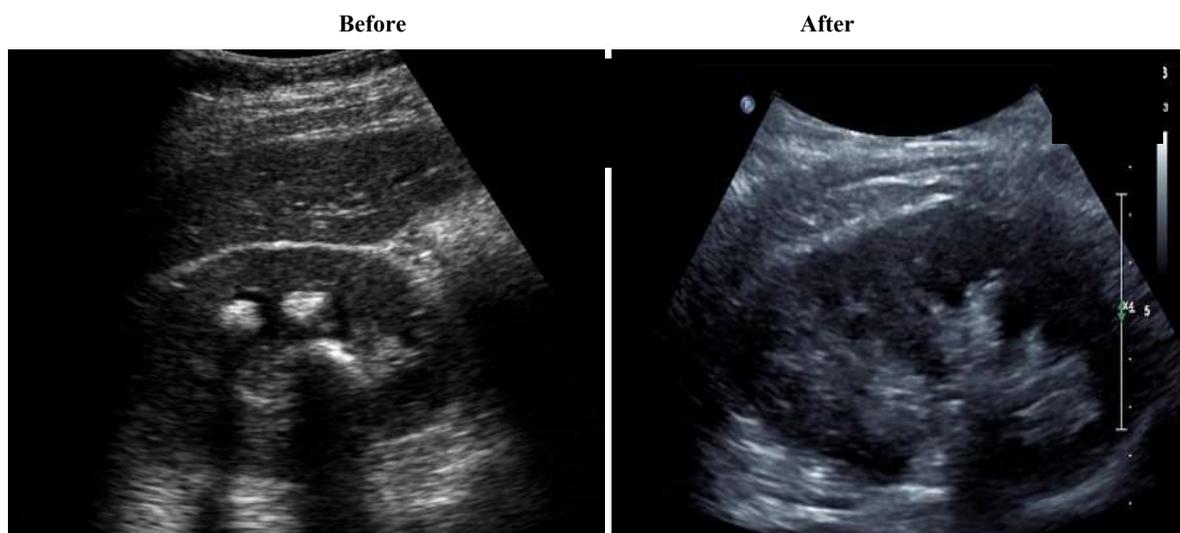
Ultrasound image before and after Aerva lanata consumption (Sample 1)
